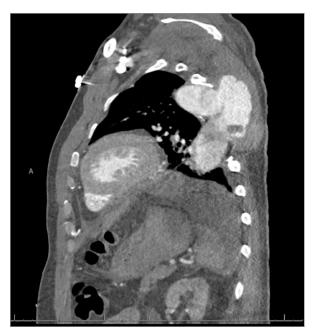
Sagittal cardiac computed tomographic angiogram demonstrates extension of the descending thoracic aorta through the chest wall into the submuscular space with pseudoaneurysm and thrombus development; there is disruption of the normal anatomy of the posterior chest wall, likely secondary to ballistic destruction.
